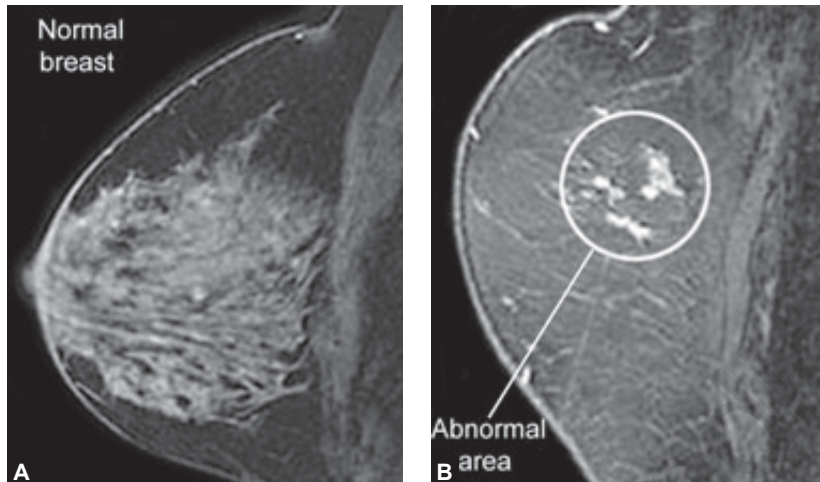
Magnetic resonance imaging of breast.
